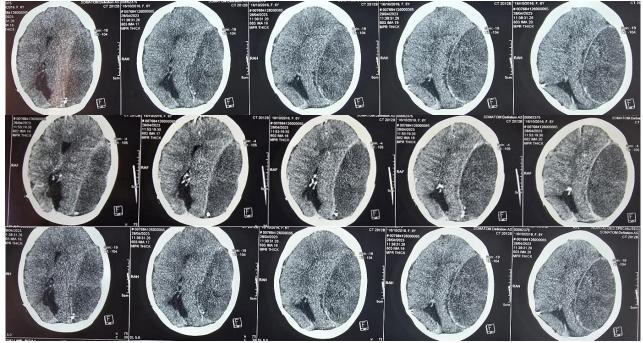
A C- cranial CT scan showing a large left hemispheric hypodense biconvex collection with a dense calcified membrane and a midline deviation
